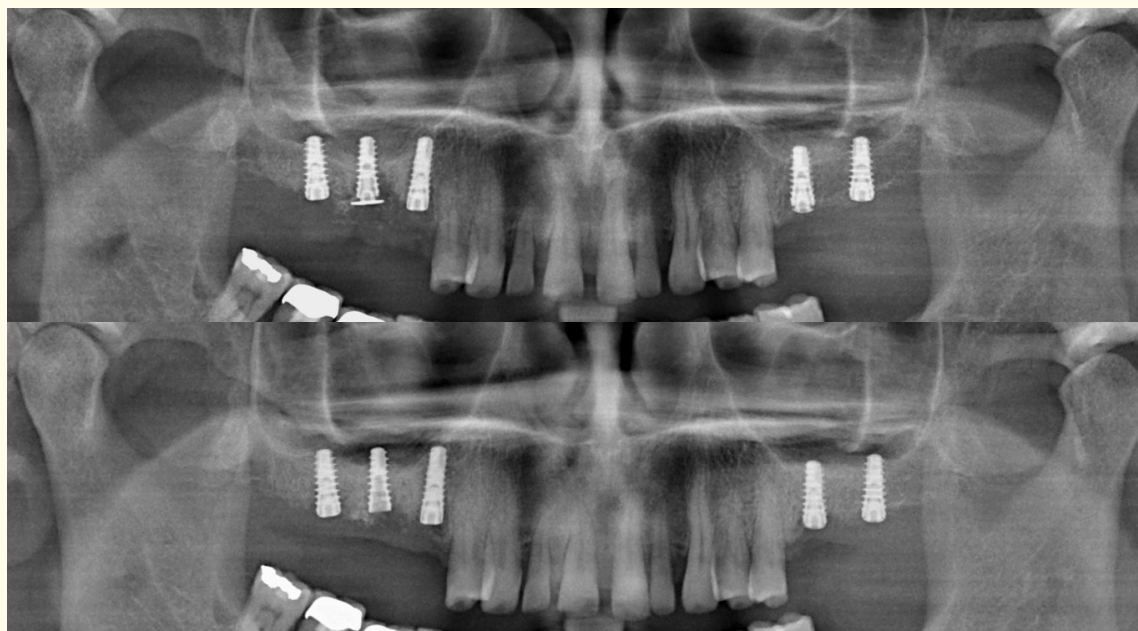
OPG X-rays from (up) the day of surgery and (down) after a five-month healing period showing osseointegration of all 5 implants.
